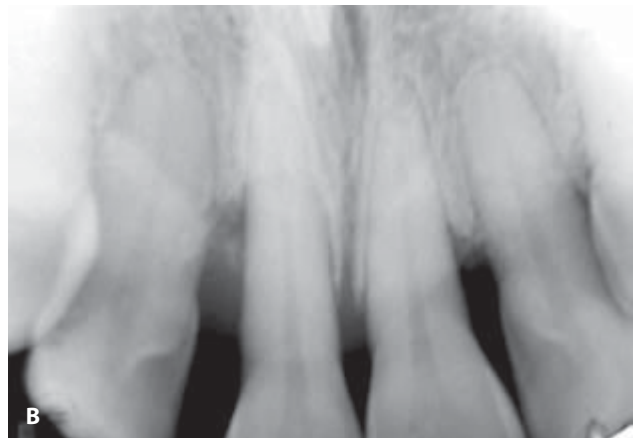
A periapical radiographic view showing thin scalloped tissue biotype. Note the spacing between the roots.
